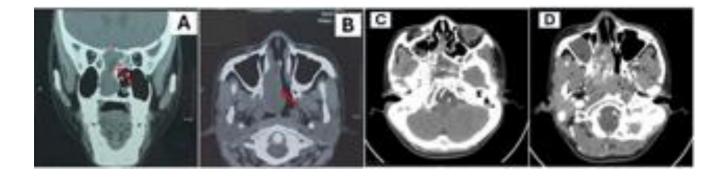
Non-contrast paranasal sinus CT scan. A) Coronal slice showing hyperdense at the right nasal cavity up to the posterior ethmoid (red arrow). B) Axial slice showing hyperdensity in the right nasal cavity and deviation of the septum contralaterally (red arrow). C) and D) Head CT angiography showing mass in the right nasopharynx, right nasal cavity, up to the sphenoid sinus, suggesting juvenile angiofibroma.
